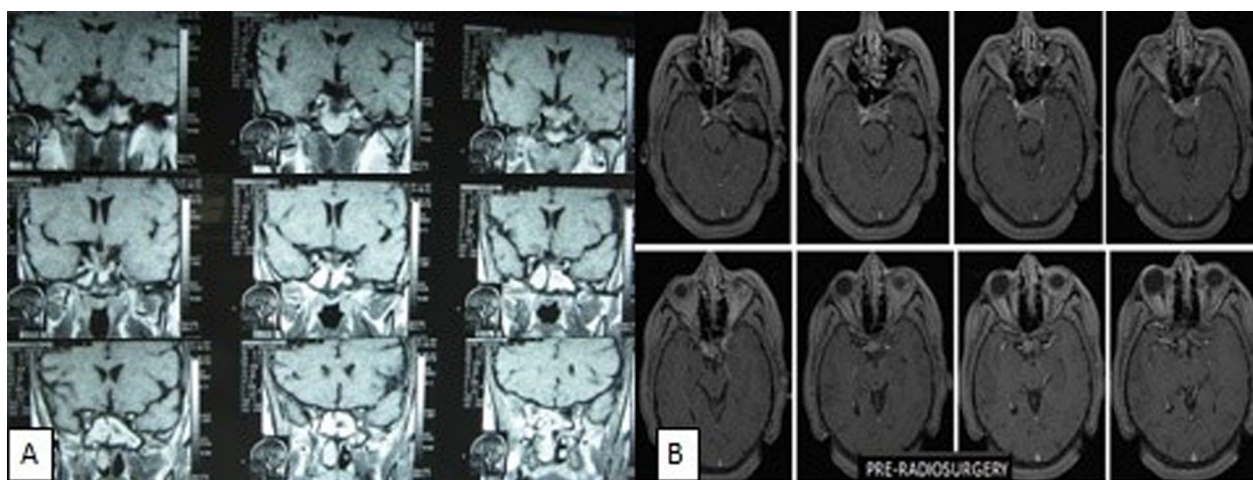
Case N° 2: MRI brain (coronal (A) and axial cuts (B)): pre-GK radiosurgery
